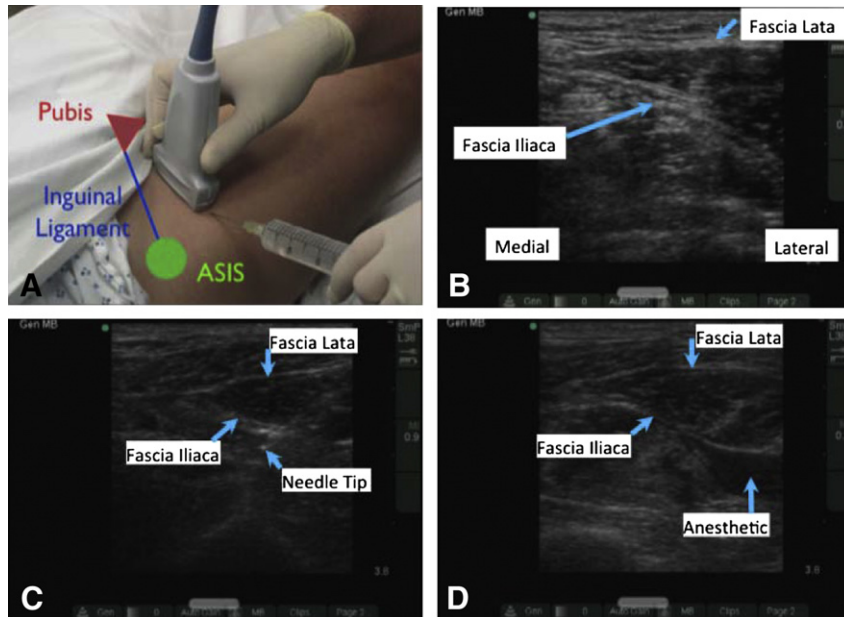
(A) Placing the ultrasound-guided fascia iliaca compartment block (UFIB). ASIS = anterior superior iliac spine. (B) Ultrasound visualization of the fascia lata and fascia iliaca. Note the medial and lateral orientation. (C) Ultrasound image just before injection. Note the needle tip deep to the fascia iliaca. (D) Image after injection of local anesthetic. Note the anechoic collection of local anesthetic just beneath the plane of the fascia iliaca.
